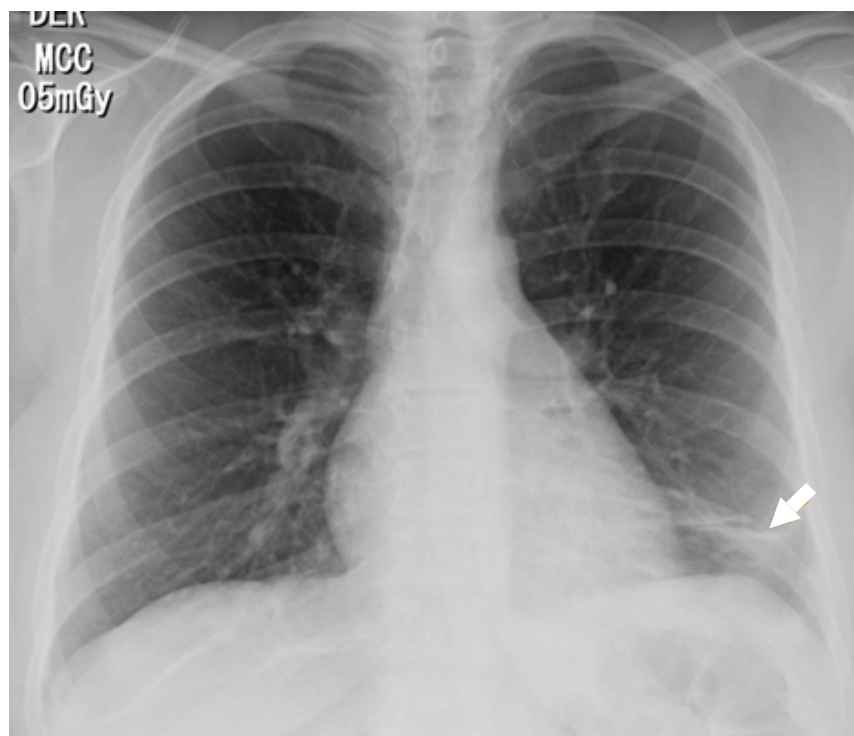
Posteroanterior chest X-ray. Image in left basal band corresponding to atelectasis (arrow).
